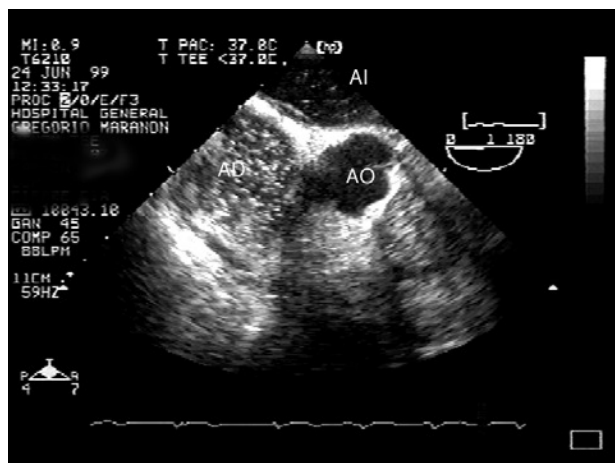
Transesophageal echocardiography in a patient with patent foramen ovale. After injection, contrast material can be seen passing into the left atrium. RA indicates right atrium; AO, aorta; LA, left atrium.
